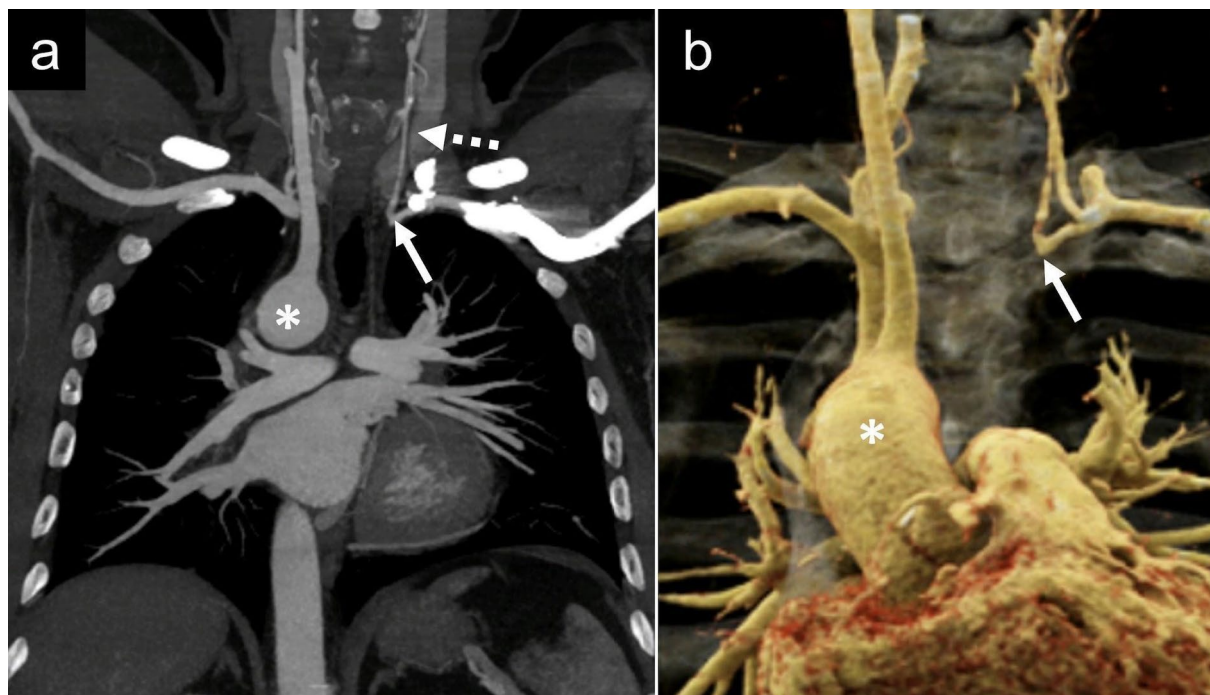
Coronal maximum intensity projection (MIP) CT image (a) and 3D cinematic VRT (volume rendering technique) image (b) demonstrate the right-sided aortic arch (a, b, asterisk) with the isolation
